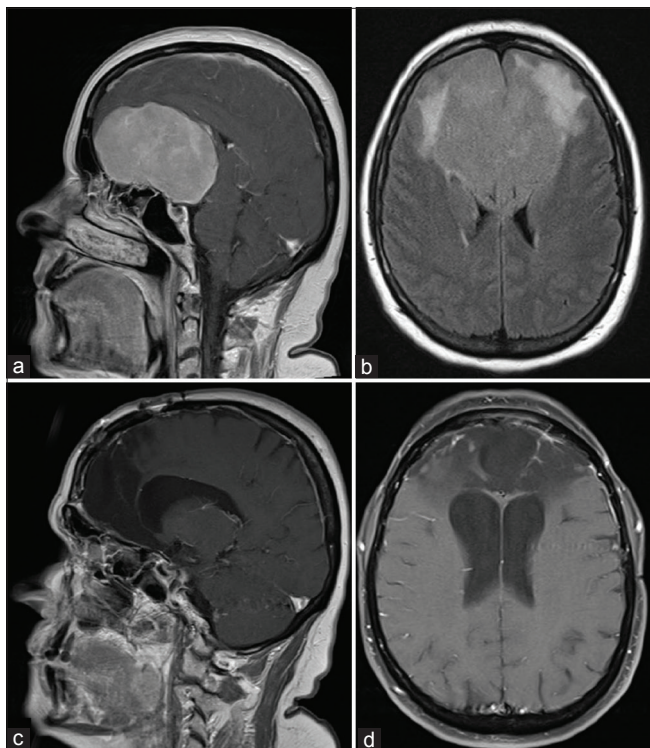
Sagittal postgadolinium-enhanced T1 magnetic resonance imaging depicting a large olfactory groove meningioma spanning the entirety of the anterior skull base from posterior table of the frontal sinuses to suprasellar region (a) with significant mass effect on the lateral horns of the ventricles and associated fluid-attenuated inversion recovery signal change. (b) Eight months after bifrontal craniotomy and tumor resection, sagittal (c) and axial (d) postcontrast views show gross total resection with associated encephalomalacia.
